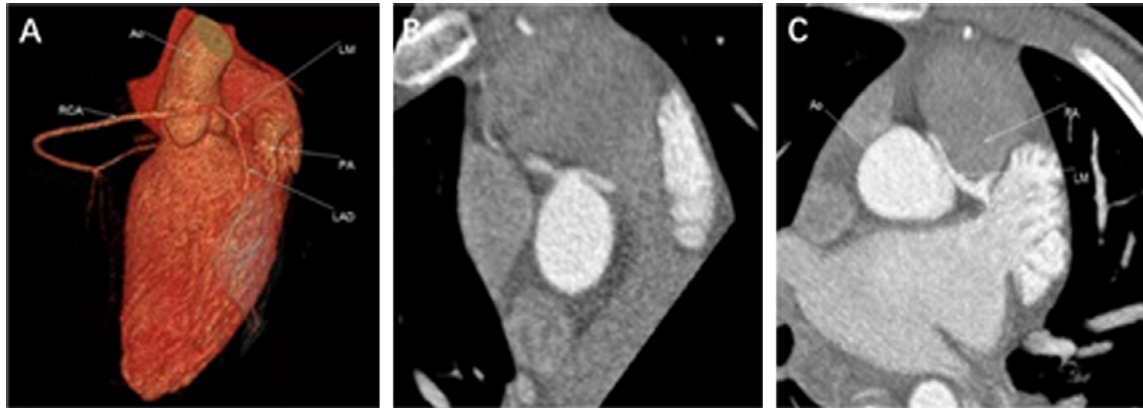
Anterior view of the 3-dimensional constructed computed tomography image of the heart (A) and axial view of the coronary computed tomography angiography (B) shows an anomalous origin of the left main coronary artery arising from the right coronary sinus; C (axial view) represents a malignant intra-arterial course between the aorta and main pulmonary artery with severe compression.
